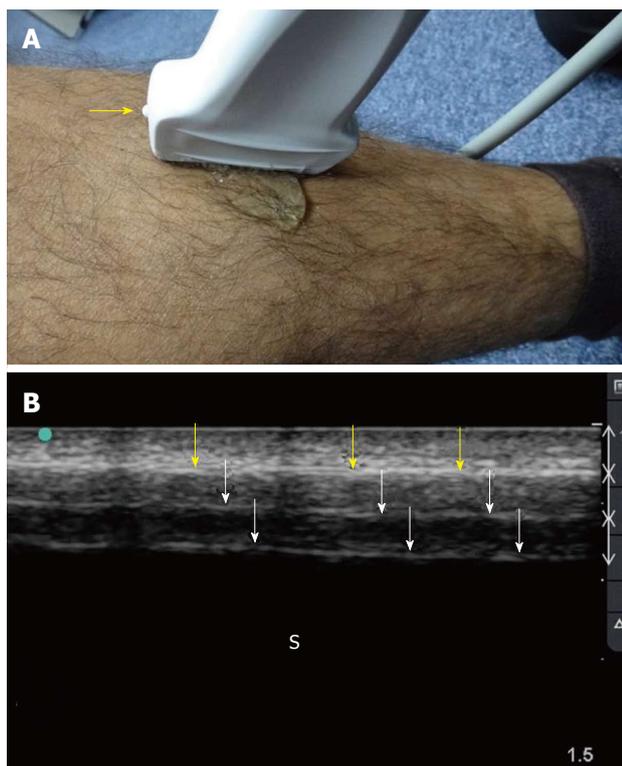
Ultrasound examination of the tibial shaft. A linear probe having a frequency of 10-12 MHz was used (A). The marker (yellow arrow) is pointing proximally. The plain surface of the tibia makes the examination easy. Normal ultrasound findings (B) include a hyperechoic line (yellow arrows) representing the cortical line of the bone. There are reverberation artifacts deeper to this line (white arrows). These are linear lines parallel to the cortex, having the same distance between them and decreasing in density. A black shadow is located deeper to that. S: Sonographic shadow of the shaft of the tibia. Ultrasound study was performed by Professor Fikri Abu-Zidan, Department of Surgery, Al-Ain Hospital, Al-Ain, UAE.
